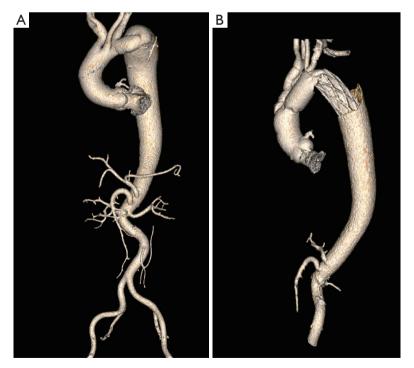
Pre- and post-operative imaging of patient No. 9. (A) Preoperative CTA demonstrating twisted coarctation; (B) postoperative CTA demonstrating normal arch anatomy and contrast agent was observed around the stent end. CTA, computed tomography angiography.
